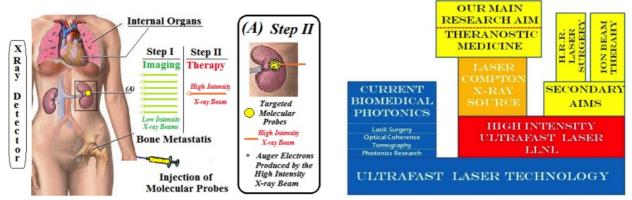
(a) Our main research area will be Theranostic: both diagnostic and therapy of diseased tissue using this novel technology. In summary, the disease targeting molecular probes will be injected to the patient and after they accumulate in the diseases tissue, imaging will be performed first using low energy X-ray beams. Once the targeted agent are localized using K-Edge imaging that provides superior contrast, high intensity beam will be focused only on the targeted agents. Auger electrons emitted by the targeted molecular probes that carries high-Z elements such as gold, iodine, gadolinium or platin will provide local targeted therapy. (b) The current biomedical photonics is based on the landscape of the ultrafast laser. Our collaborators at LBNL has ultra-intense laser technology that is the basis of Laser Compton X-ray Source. Although our main aim is to use this novel source for theranostic medicine, our secondary aim will be utilizing this technology for biophotonics applications such as laser surgery and for ion beam therapy in the future.
